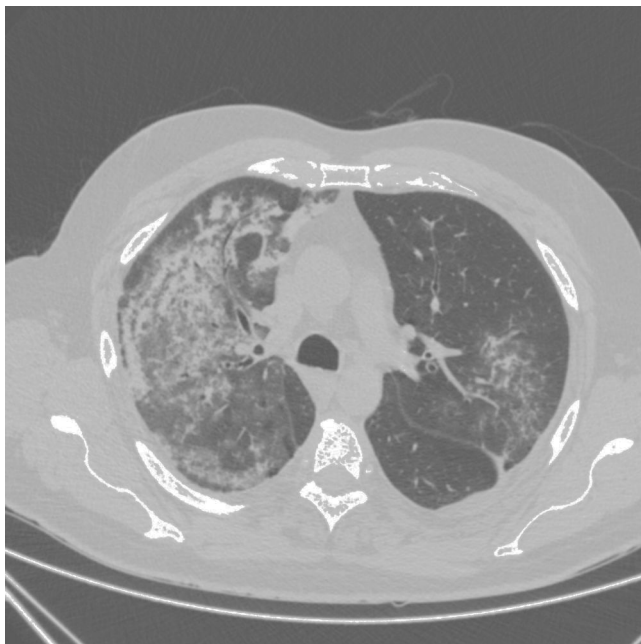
Image of high-resolution chest CT scan revealing an alveolar pattern compatible with pulmonary haemorrhage.
